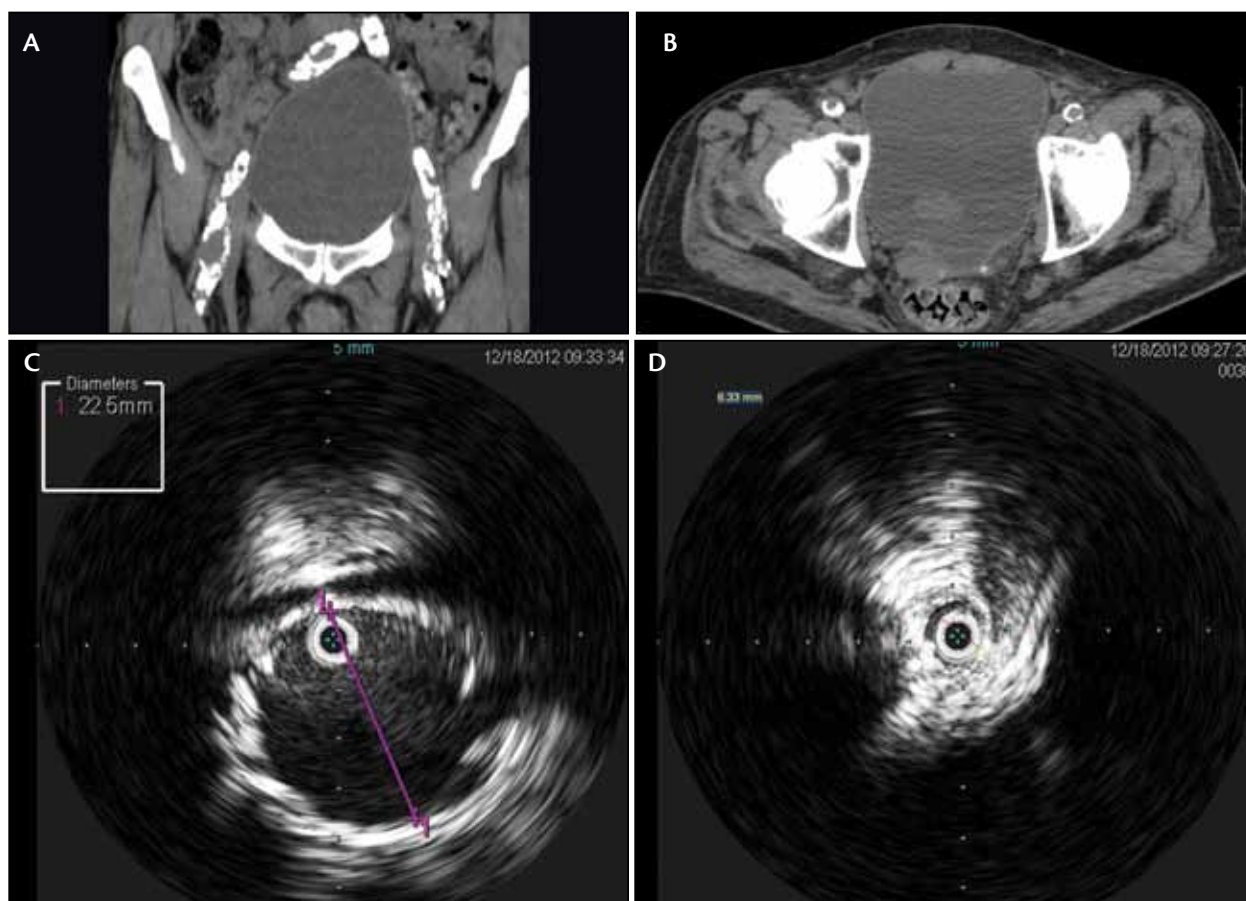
The maximum image projection CT of the femoral and iliac arteries reveals severe calcifications (A). A CT slice image at the access sites reveals circumferential calcification of the left common femoral artery and near-circumferential calcification of the right common femoral artery (B). The intravascular ultrasound image reveals the infrarenal aortic neck diameter to be 22.5 mm (C). The intravascular ultrasound image reveals circumferential calcification of the left common iliac artery that measured 6.3 mm in maximal diameter (D).
